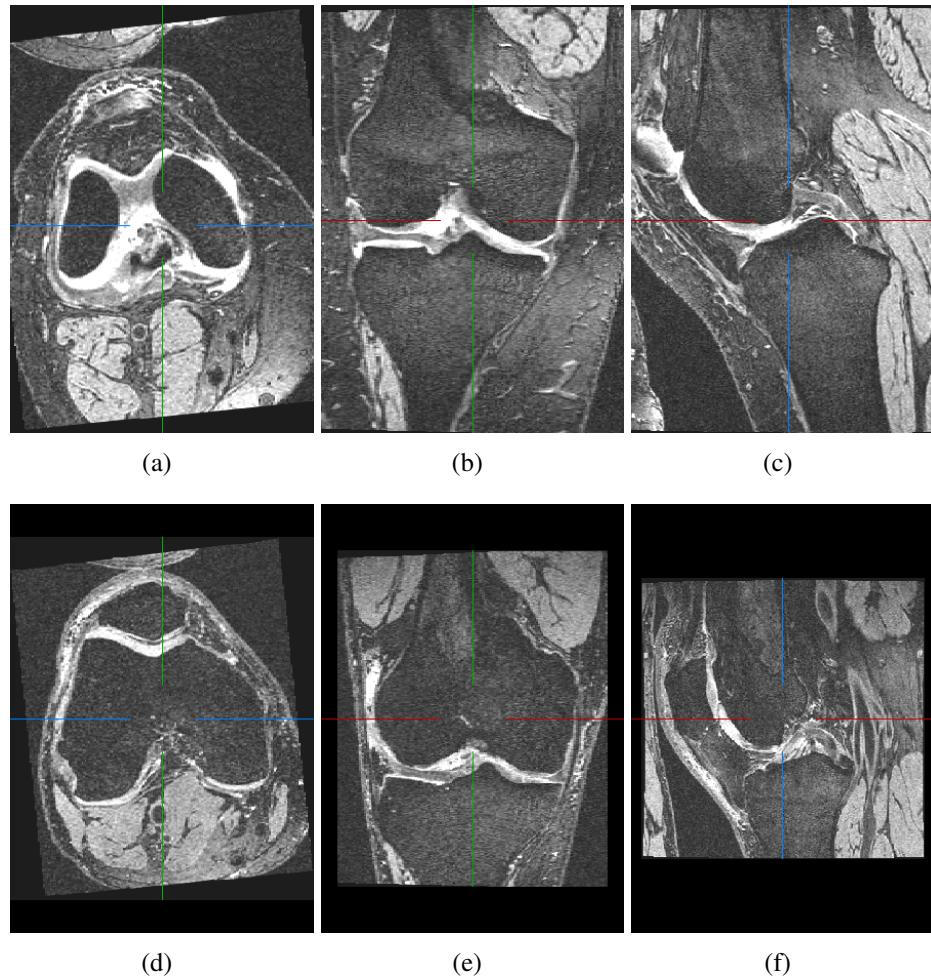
Two examples of magnetic resonance imaging (MRI) data, 3D dual echo steady state sequence (3D DESS) from OAI dataset. Figure shows three planes: axial plane (a,d), coronal plane (b,e) and sagittal plane (c,f).
